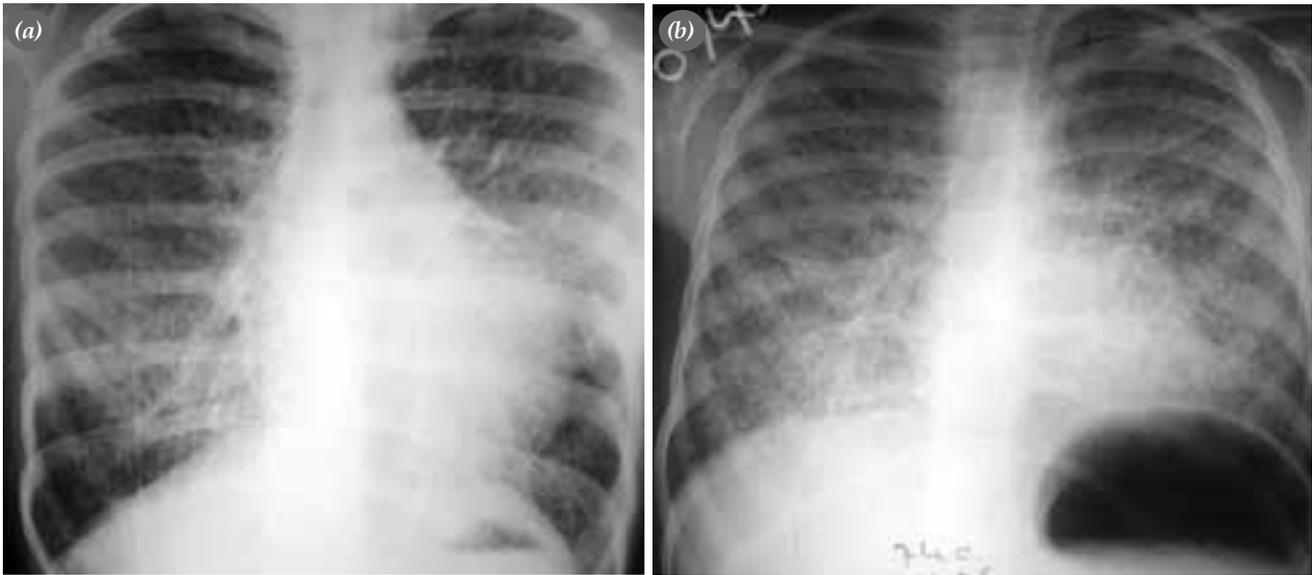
Chest roentgenograms of the patient (a) on admission (in 1991) and (b) at the end of a 12-year follow-up.
